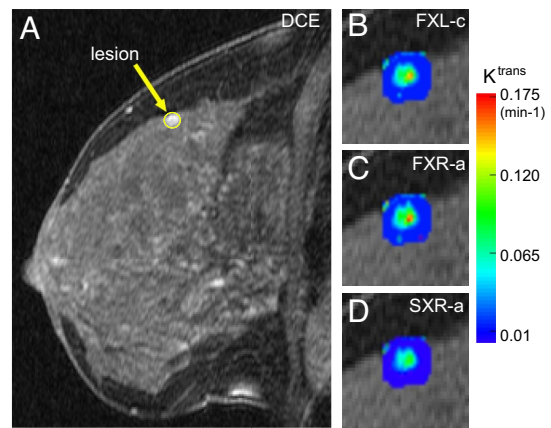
Breast MR images. (A) A sagittal, fat-suppressed breast DCE-MRI image containing a malignant IDC tumor (circled contrast-enhanced region-of-interest) is shown. (B–D) Pharmacokinetic K^{trans} parametric maps of the tumor, generated by the SM (FXL-c) (B) and two members of the SSM family (FXR-a; C) and (SXR-a; D), are shown. (Magnification: $\times 2.5$; B, C, and D relative to A.)
